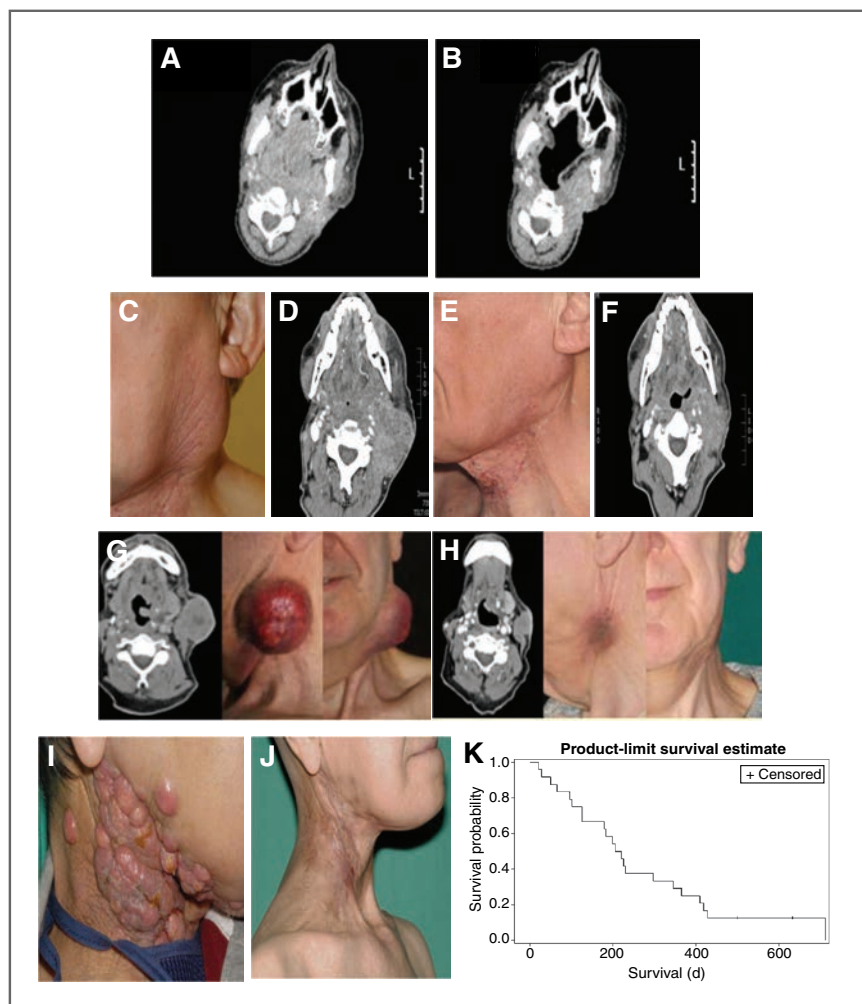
Treatment responses in patients in a phase I study of intravenous reovirus combined with platin/taxane doublet in patients with incurable or relapsed/metastatic head and neck cancer. Computed tomographic imaging before (A) and after three cycles of treatment with reovirus given with carboplatin and paclitaxel (B). This patient had oropharyngeal cancer (tonsil). The response was sustained through eight cycles of treatment, despite previous treatment with chemoradiation, palliative chemotherapy (cisplatin and 5-fluorouracil), and targeted therapy with an investigational monoclonal antibody. Before (C and D) and after three cycles of treatment (E and F). The patient had a supraglottic SCC and had been
